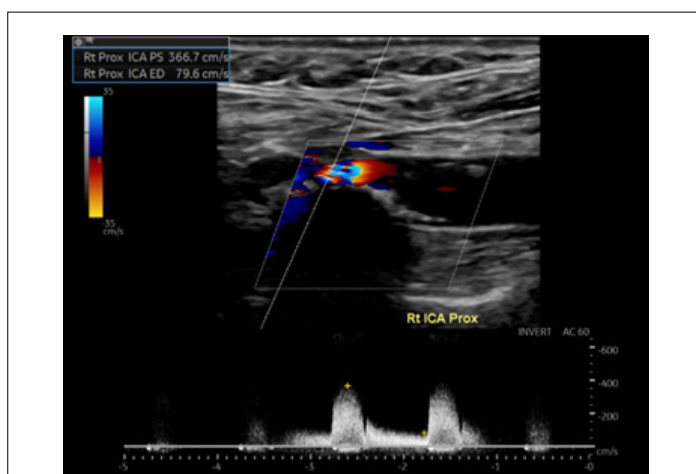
Carotid Doppler US before IVL showing severe shadowing distal to a severe stenosis due to calcification.
